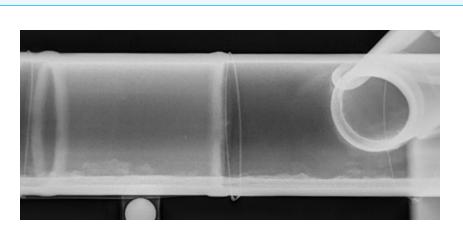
A digital radiograph showing debris in pipe before cleaning.
